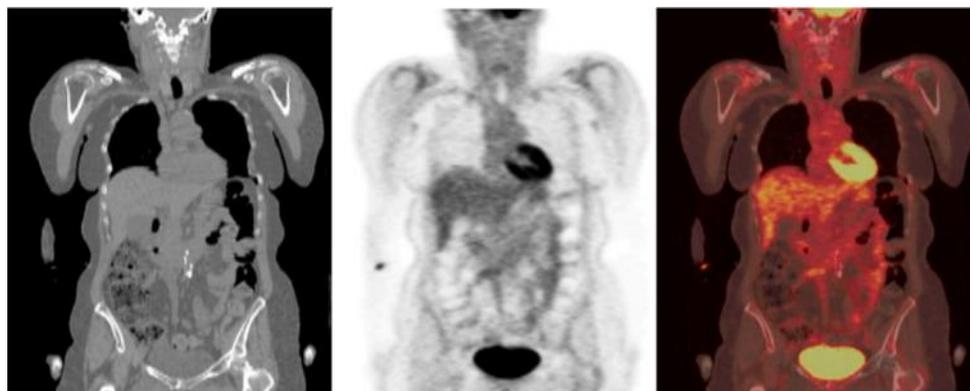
Normal Bio distribution of PET/CT image using ¹⁸F-FDG radio isotope mCt-Flow PET Fused WB PET/CT scan.
